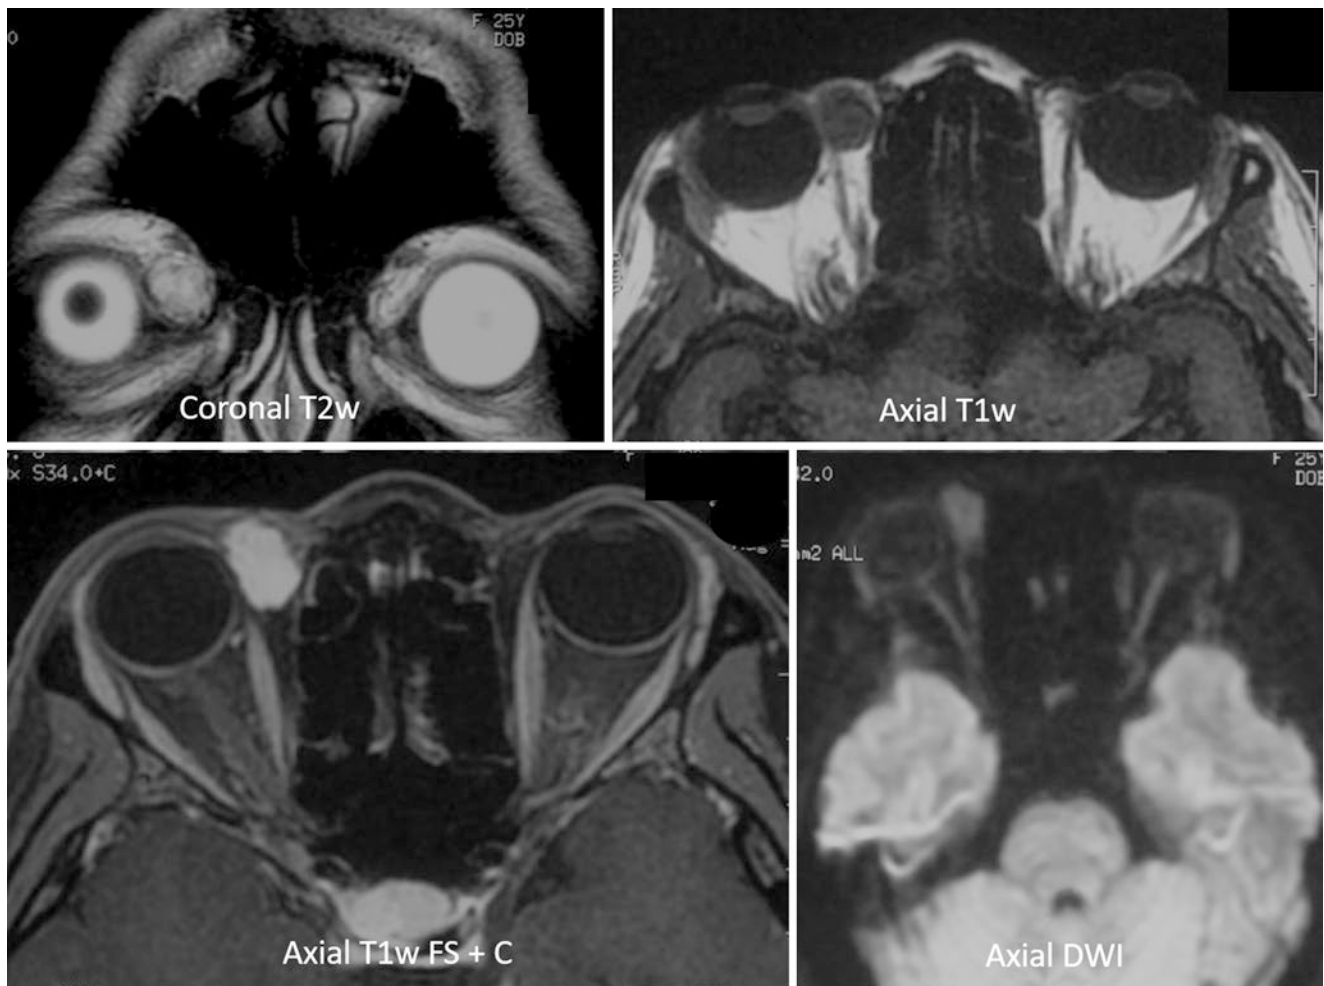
MRI of the orbits: coronal T2w, axial T1w, axial T1w FS + C and axial DWI sequences, showing a well-circumscribed extra-conal mass, hyperintense on T2w, isointense to brain on T1w images
